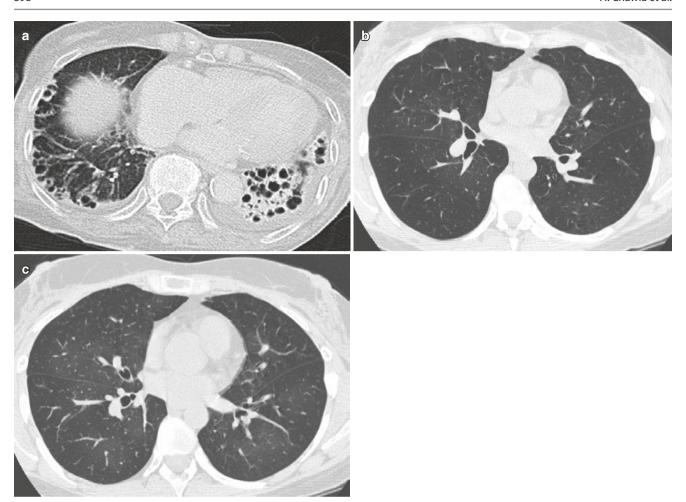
RA with thoracic manifestations. (a) Cystic bronchiectasis with left pleural effusion. Obliterative bronchiectasis in another patient with RA. (b) Inspiratory and (c) expiratory CT image show air-trapping
